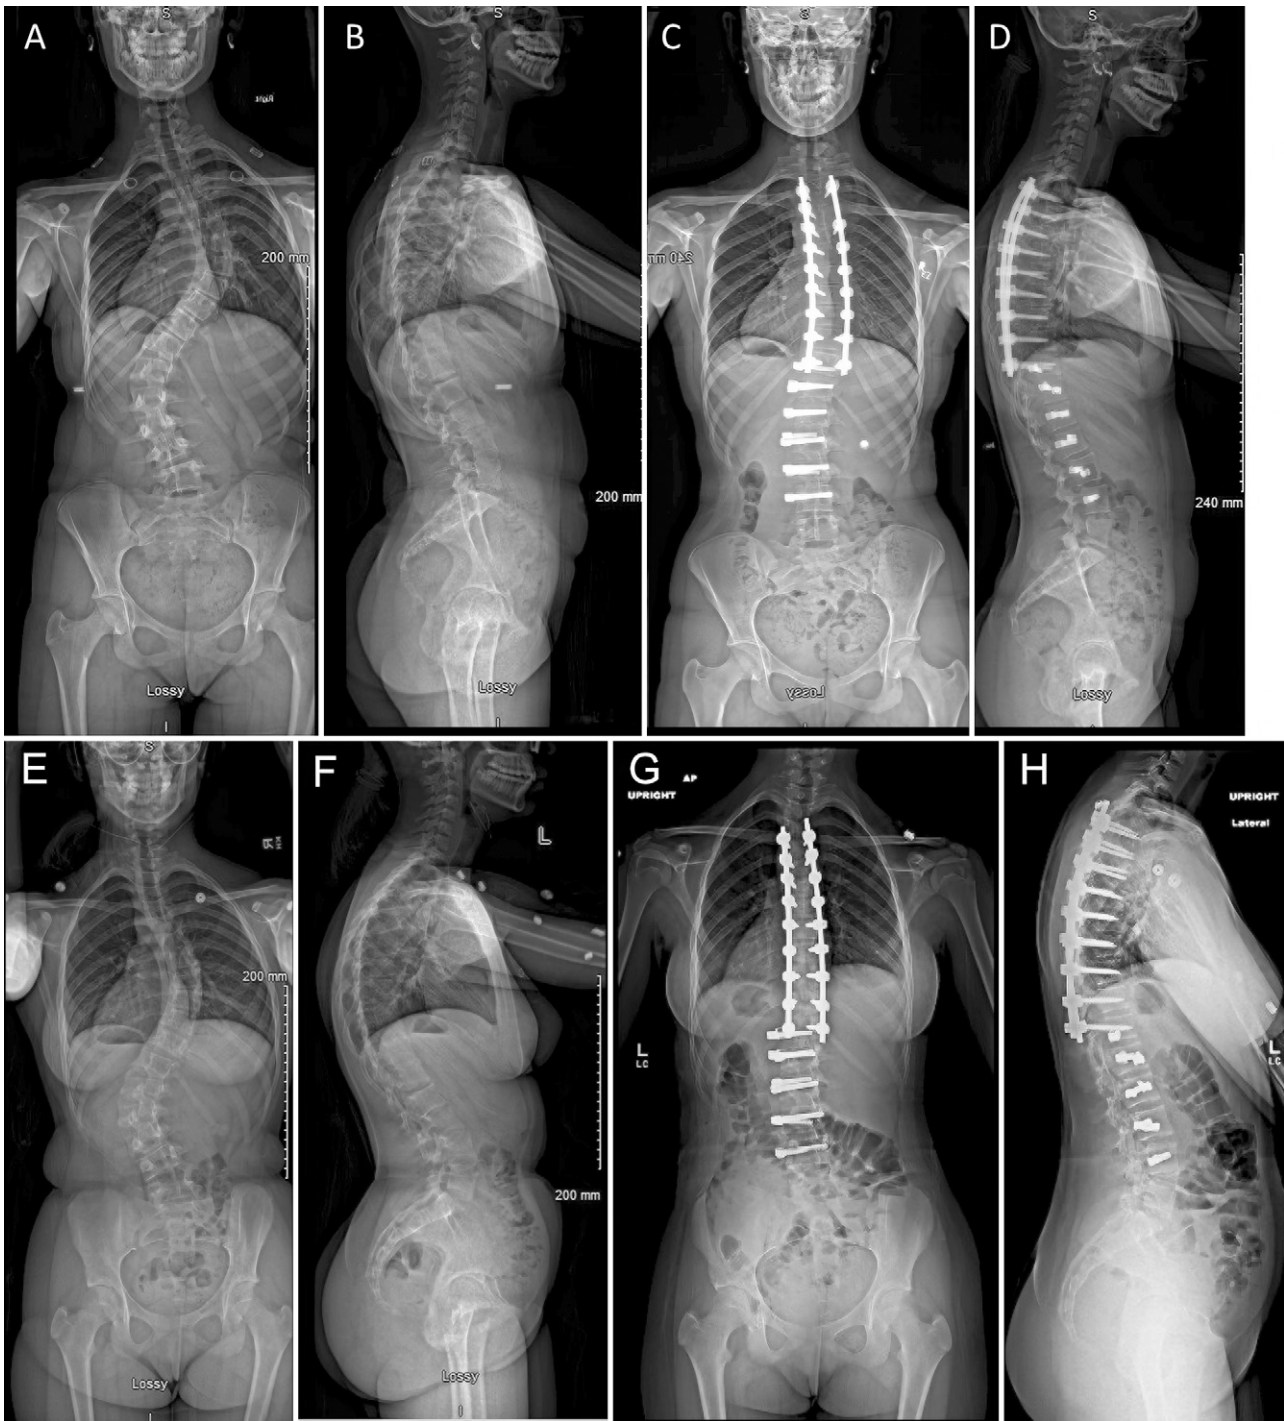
A–H: Posteroanterior (PA; A) and lateral (B) radiographs obtained in a 14-year-old girl with AIS who presented with a Lenke 6C double major curve. PA (C) and lateral (D) radiographs after the girl underwent a staged T1–10 PSF and T10–L4 AVBT. PA (E) and lateral (F) radiographs obtained in a 14-year-old girl with AIS who presented with a Lenke 6C double major curve. PA (G) and lateral (H) radiographs obtained after the girl underwent a staged T3–11 PSF and T11–L4 AVBT.
